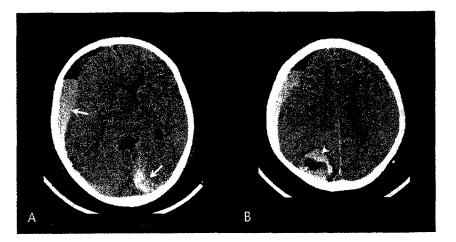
Images obtained from a 2-year-old boy with congenital heart disease and ECMO. Axial computed tomographic images show bilateral subdural hematomas (A, arrows) and right-side parietal intracerebral hematoma (B, arrowhead) with low-density over high-density fluid levels.
